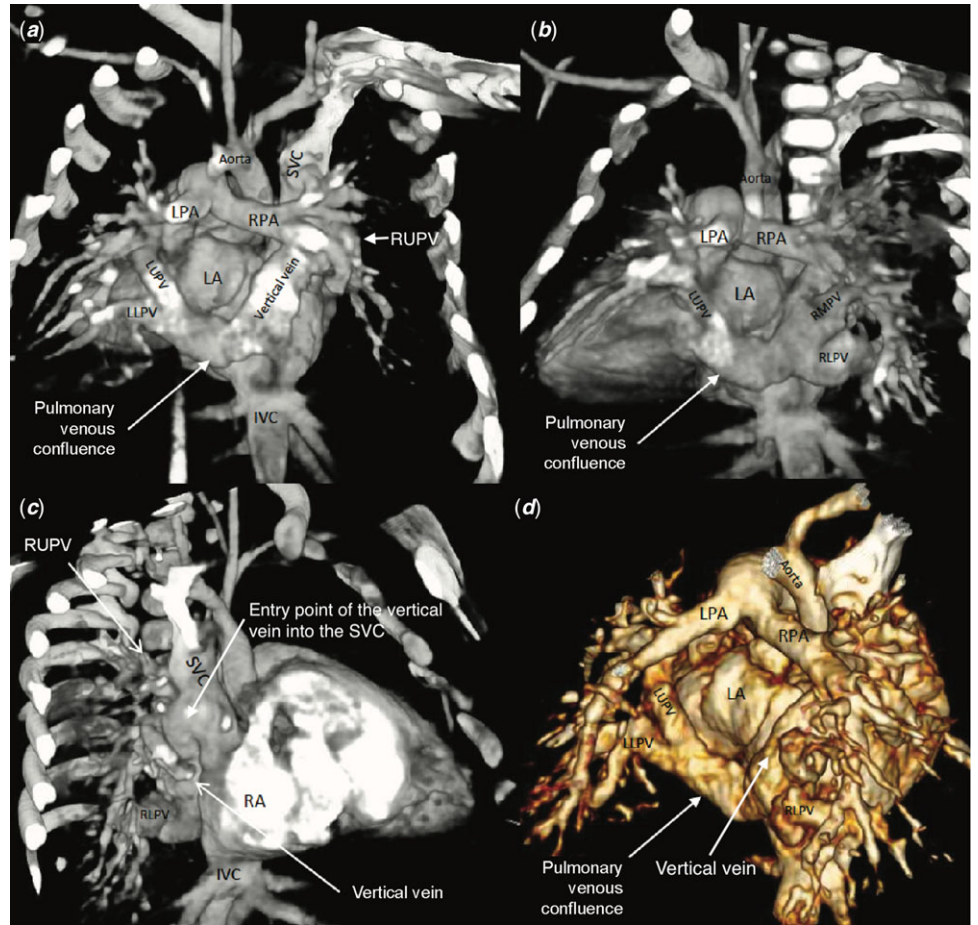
CT angiography with three-dimensional reconstruction. (a) The left upper (LUPV) and left lower (LLPV) pulmonary veins drained into the pulmonary venous confluence. The vertical vein ascended beside the left atrium and entered the superior vena cava (SVC). (b) The right middle (RMPV) and right lower (RLPV) pulmonary veins drained into the pulmonary venous confluence. (c) The right upper pulmonary vein (RUPV) entered the SVC separately from the vertical vein. (d) In the superior-posterior view, the pulmonary venous confluence is clearly visible. Atria (left, LA; right, RA); pulmonary arteries (left, LPA; right, RPA); inferior vena cava (IVC).
